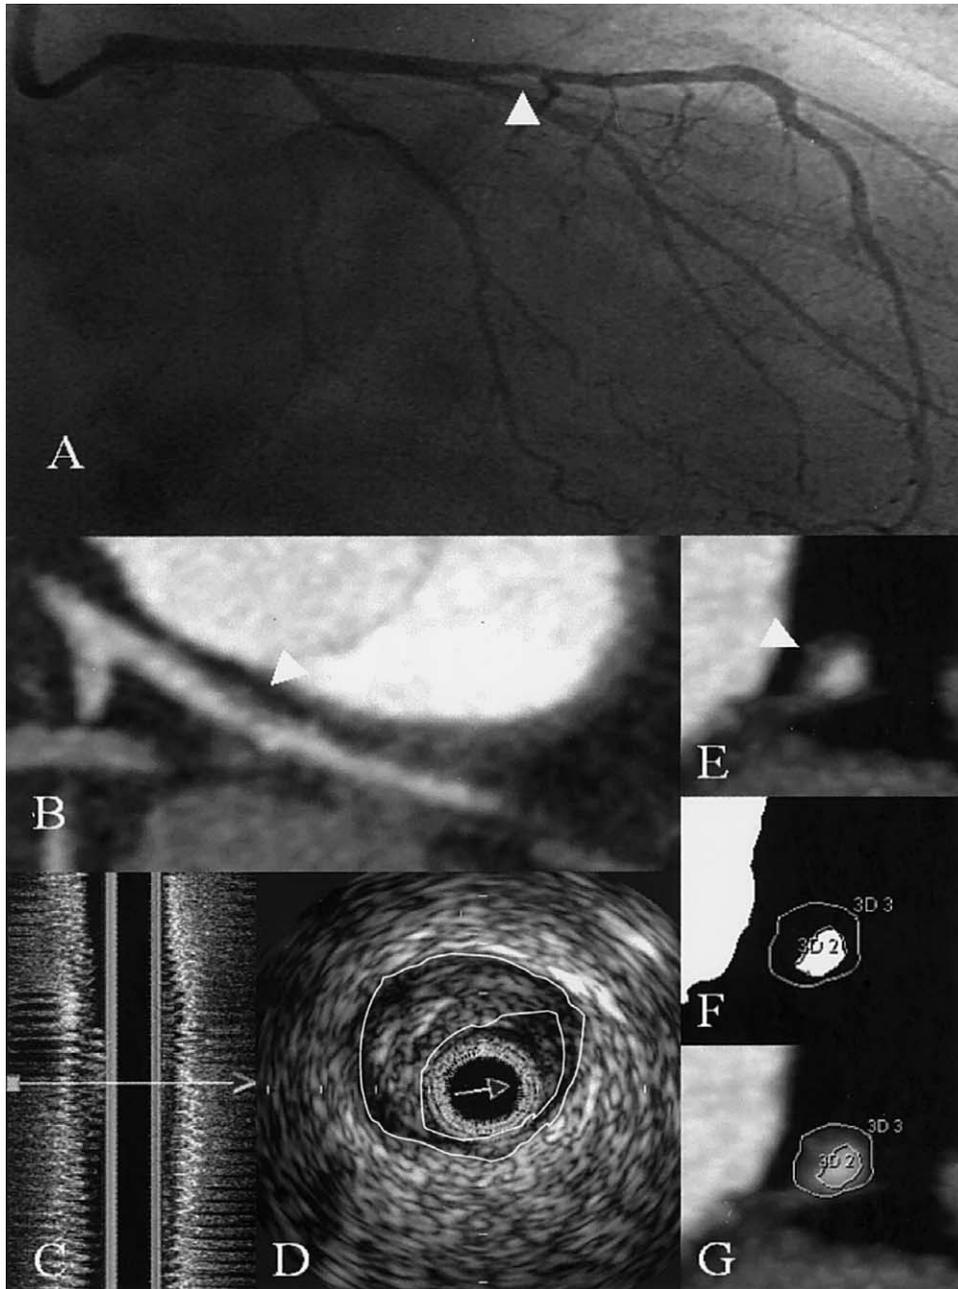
Angiographically nonobstructive lesion of the left anterior descending artery. (A) Invasive angiogram: arrow indicates a nonobstructive smooth lesion. (B) 64-slice computed tomography: arrowheads indicate a noncalcified plaque in the left anterior descending artery. (C) Intravascular ultrasound: longitudinal reconstruction. (D) Intravascular ultrasound cross section: lumen area 4 mm², plaque area 11 mm². (E) Cross-sectional view of the coronary vessel. (F) Window setting for lumen measurements: width is reduced to 1 HU, window level is set to 65% (210 HU in this case) of the mean intensity measured in the lumen. (G) Window level to determine outer vessel boundaries (width at 155% of mean value within the lumen, level at 65% of mean value). Lumen area is 4 mm², plaque area is 1 mm².
